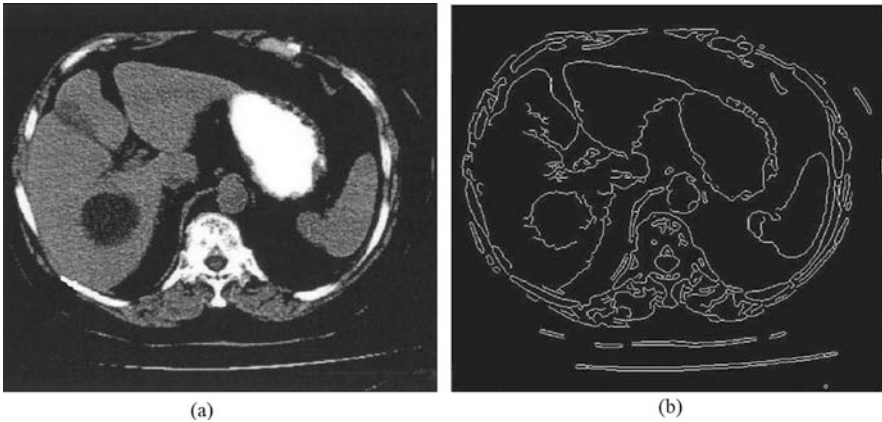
An example of edge detection technique. (a) Original abdomen CT image and (b) result of applying edge detection technique on abdomen CT image (Aggarwal 2010)
